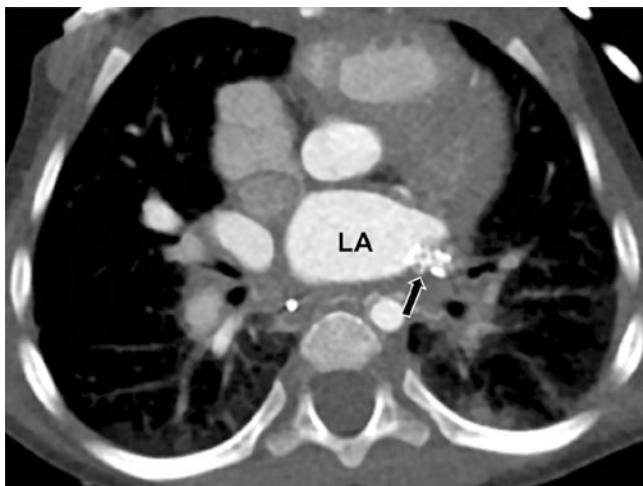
A 2-month-old girl with pulmonary vein stenosis treated with stent placement. Axial enhanced CT image shows a metallic stent (arrow) in the proximal left lower pulmonary vein
